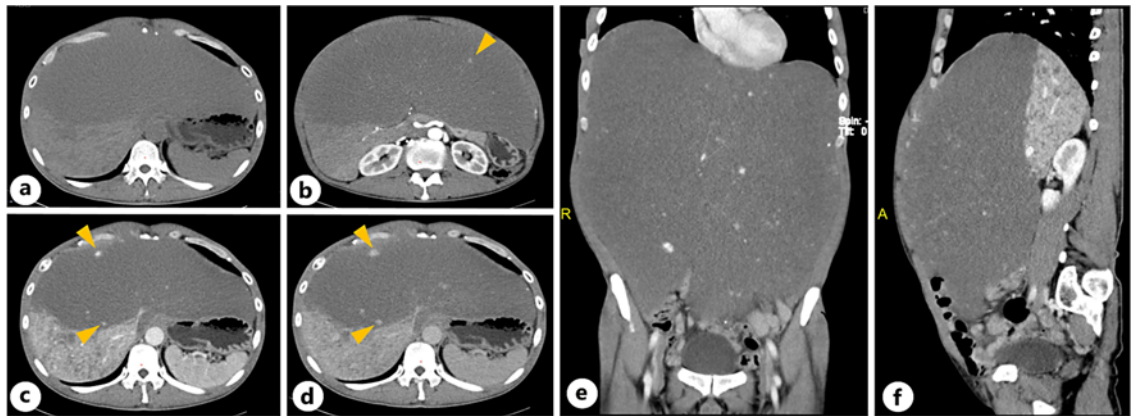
Axial views of plain CT (a) and enhanced CT (b–d) showed the enhancement pattern of the mass. Coronal (e) and sagittal (f) views of the enhanced CT image showed the size of the mass.
